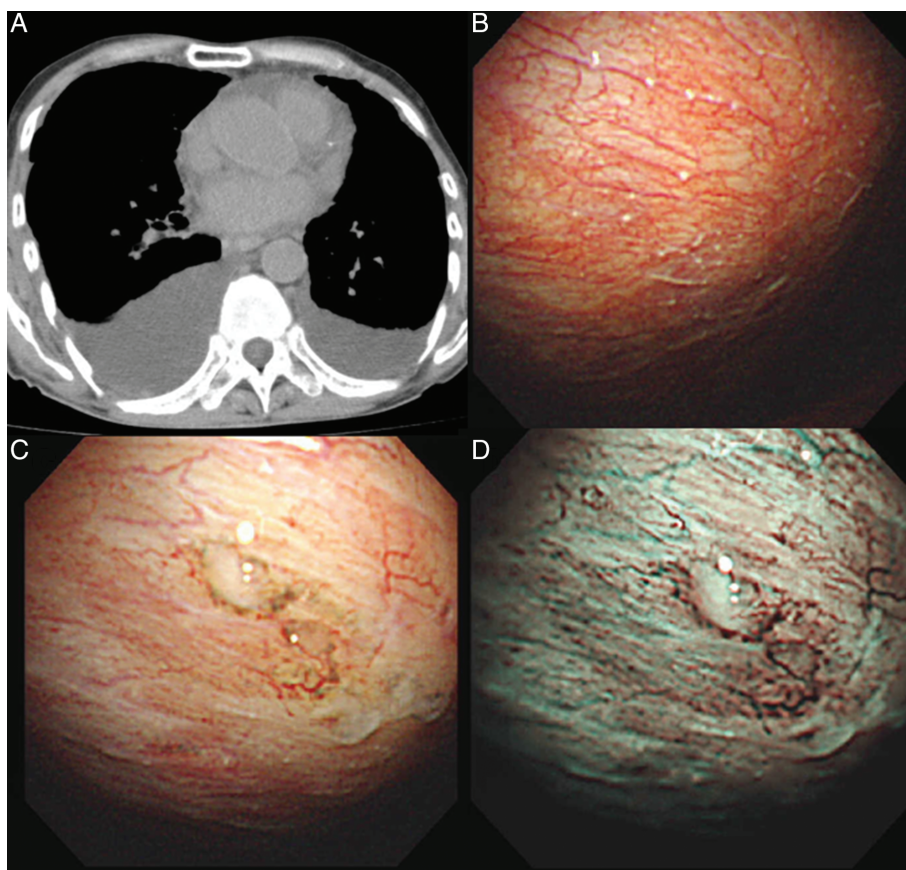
(A) Chest computed tomography (CT) showed bilateral hydrothorax with no pleural thickening. (B, C) Multiple white nodules were seen in visceral pleura with white light (WL). (D) Narrow-band imaging (NBI) demonstrated dilative vessels that were seen around nodules.
